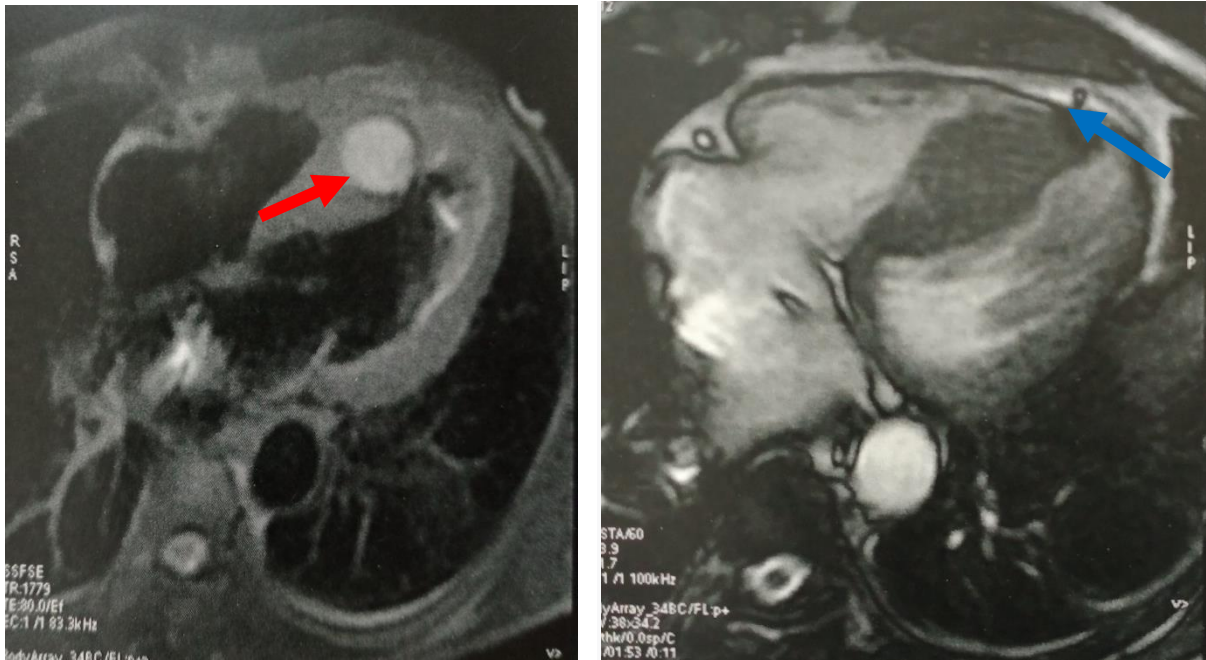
Cardiac MRI, transversal cross-section: Cystic mass with fibrous capsule of the SIV measuring 50mm x 30mm (red arrow) with an effusion blade next to the inferior wall of the LV/RV (blue arrow).
